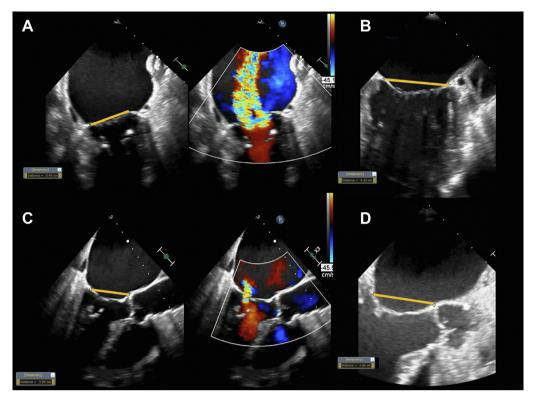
Echocardiographic assessment of mitral annular dimensions. (A) and (B), 2-dimensional measurement of intercommissural annular diameter in secondary mitral regurgitation. (C) and (D), 2-dimensional measurement of anteroposterior annular diameter of mitral valve.
